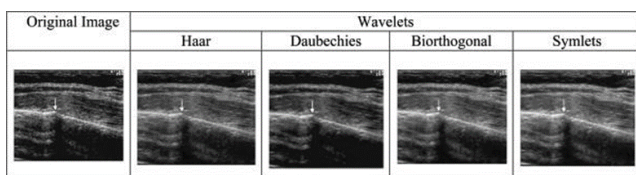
Rib fracture with callus formation ultrasound image.
